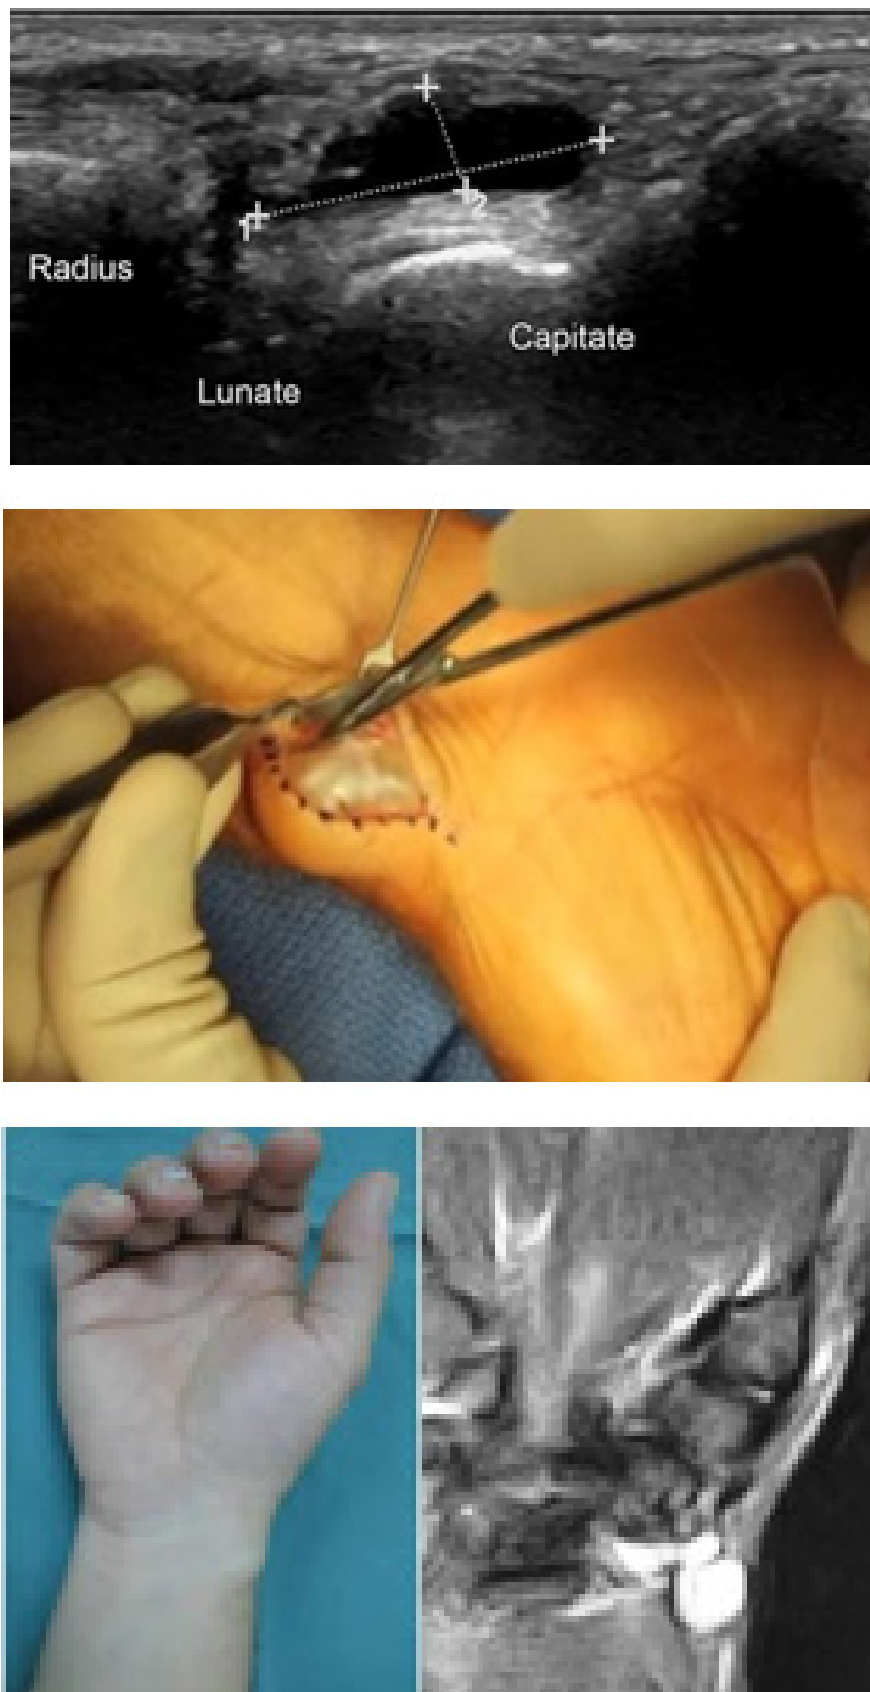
Ultrasound of ganglion cyst. b: Ultrasound of ganglion cyst. c: MRI of ganglion cyst.
